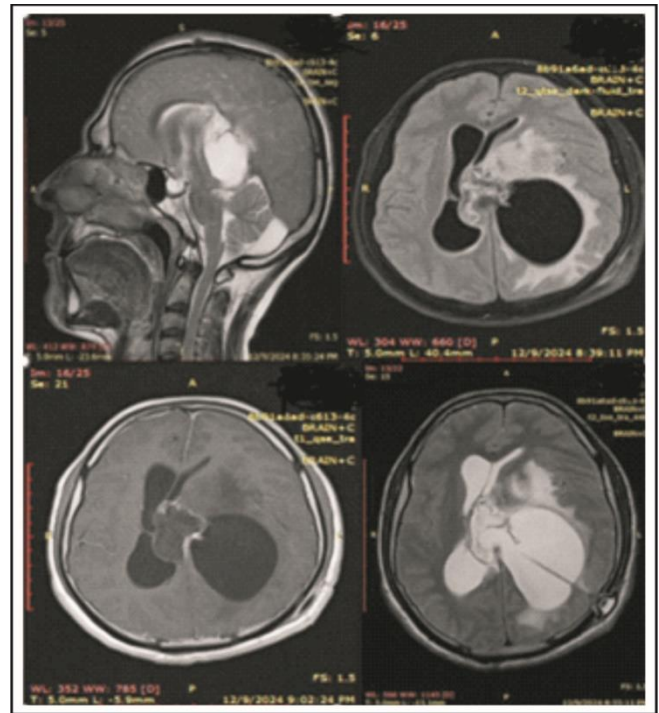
Different MRI Sequences Showing Left Large Intraventricular Epidermoid Cyst with more entrapment of the left occipital horn of the lateral ventricle. (Permission taken to use the scan from patients)
